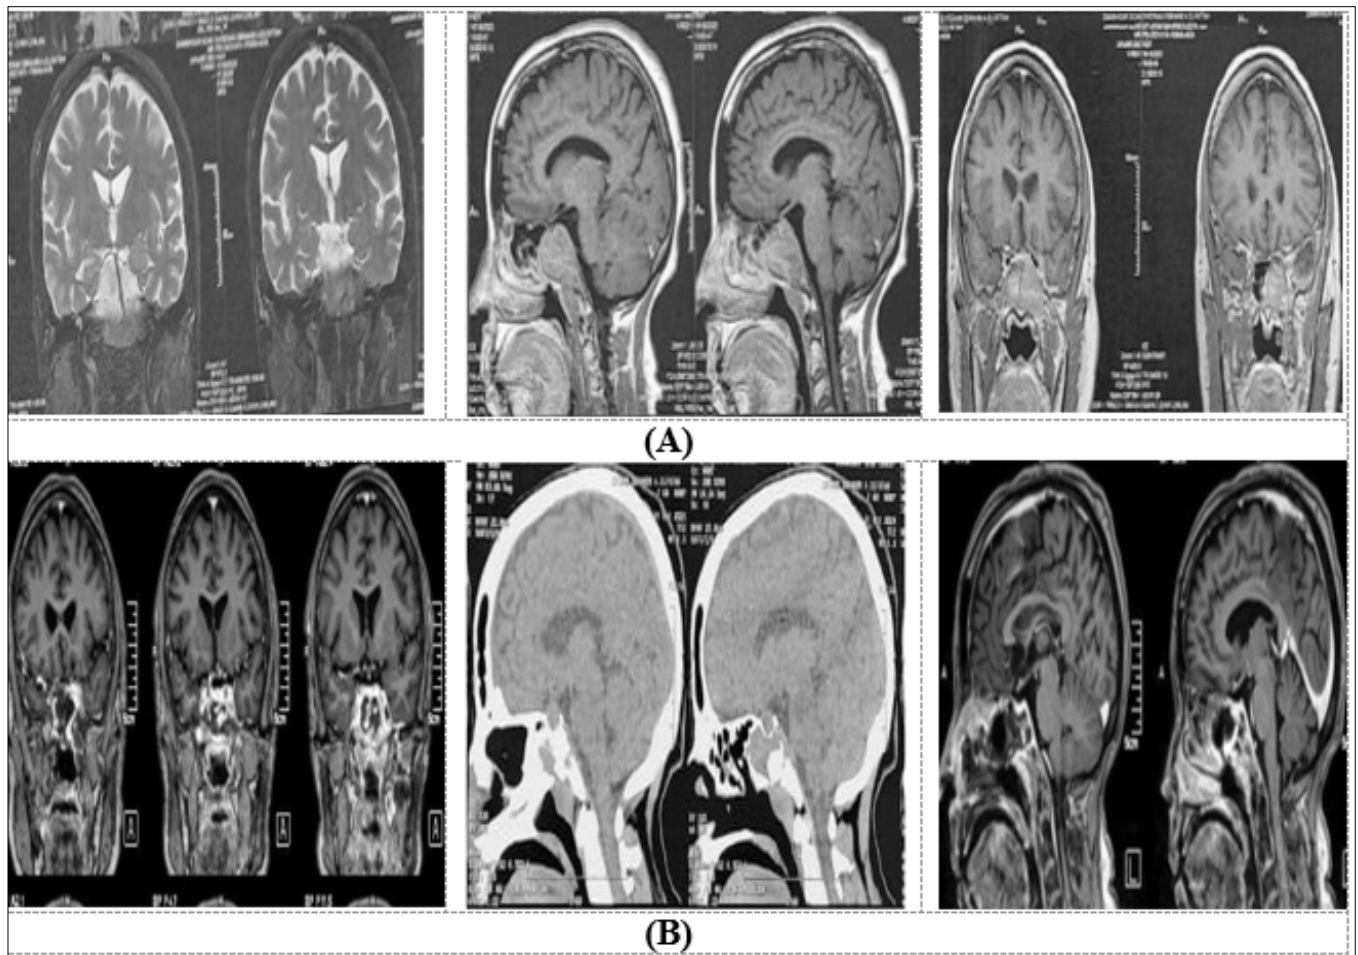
Computed tomography and contrasted magnetic resonance imaging brain of clival lesion chordoma (A) Pre-operative and (B) Post-operative follow up
